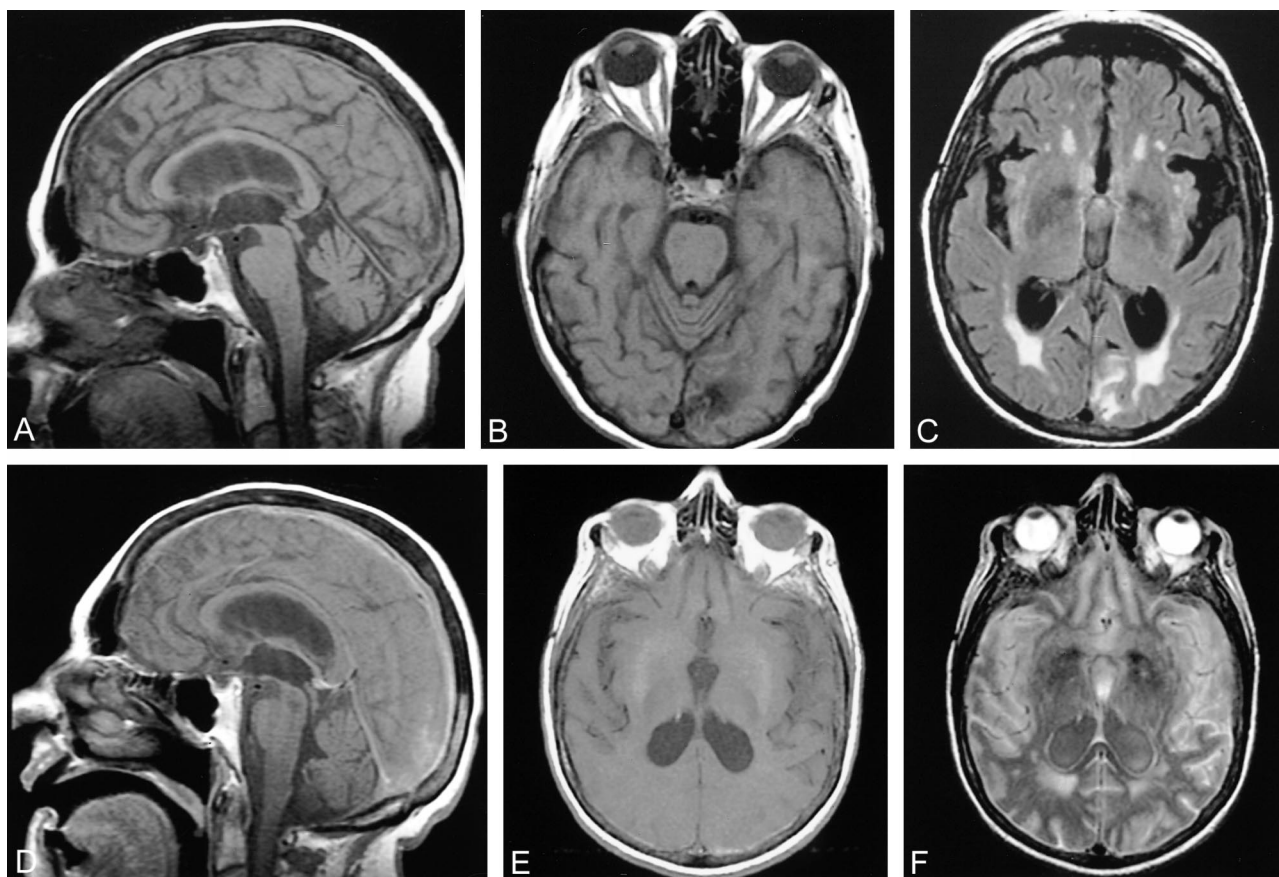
Sagittal (A) 500/8/1 (TR/TE/excitation) and axial (B) 566/12/1 precontrast T1-weighted and axial FLAIR (C) 10002/97.5/1 images of the brain demonstrate normal signal intensity of the CSF with normal contrast enhancement between the CSF and adjacent brain. Sagittal (D) 500/8/1 and axial (E) 566/12/1 precontrast T1-weighted images 10 days later, demonstrate increased signal intensity within the subarachnoid space, manifested by an isointense appearance of the sulci as compared with the adjacent brain. Additionally, there is increased signal intensity within the ocular globes on the axial image. The axial FLAIR (F) 10002/97.5/1 image demonstrates diffuse significant increased signal within the subarachnoid space and the ventricles. A–F were filmed at the same values for window and level, and were performed on the same scanner.
